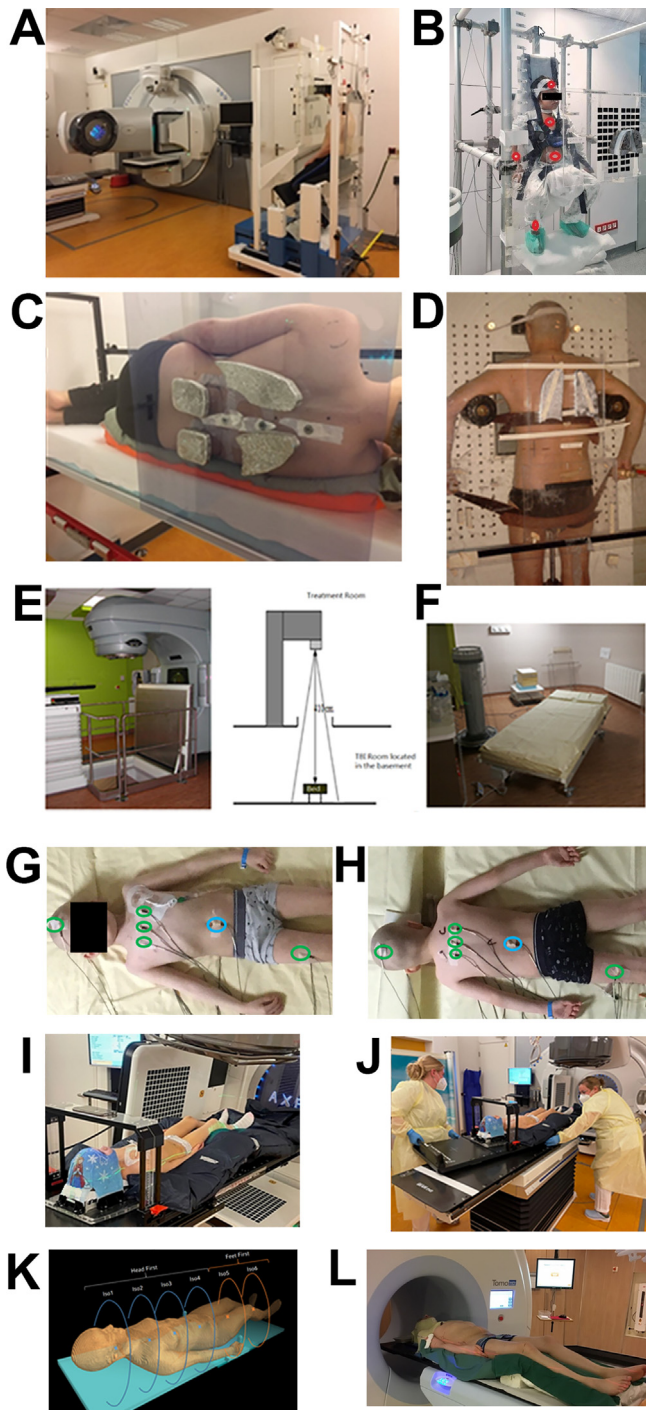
Examples of setup for conventional TBI and highly conformal TBI. Setup with “chair” construction for AP-PA irradiation, with beam spoilers and blocks for lungs, kidneys and lenses in this setting (A). Setup with stool-sitting position for AP-PA irradiation, with beam spoilers and blocks for lungs, in vivo dosimetry diodes attached (red circles) (B). Setup with “bed” construction for AP-PA irradiation in lateral decubitus position, with beam spoilers and blocks for lungs and kidneys in this setting (C). Setup in “standing” position for AP-PA irradiation, with beam spoilers and blocks for lungs (D). Setup with “bed” construction for AP-PA irradiation, with patient in supine and prone position during treatment (E–F). Patient with diodes attached for in vivo dosimetry during irradiation; homogeneity check diodes circled green, dose verification check diode at prescription point circled blue (G + H). Patient in treatment position for VMAT TBI on rotatable tabletop (I + J). Patient is distracted with movie on smartphone. 3D CT reconstruction image of patient >150 cm with 6 isodose planes and Head First/Feet First planning area for VMAT TBI indicated (K). Patient in treatment position for TomoTherapy TBI (L).
